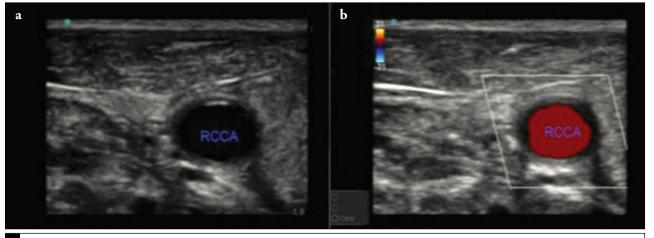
a, b. Ultrasonographic appearance of the right common carotid artery (RCCA) with the absence of the right internal jugular vein. The image was obtained during the Trendelenburg position and Valsalva maneuver. (a) RCCA (b) RCCA with color Doppler imaging
